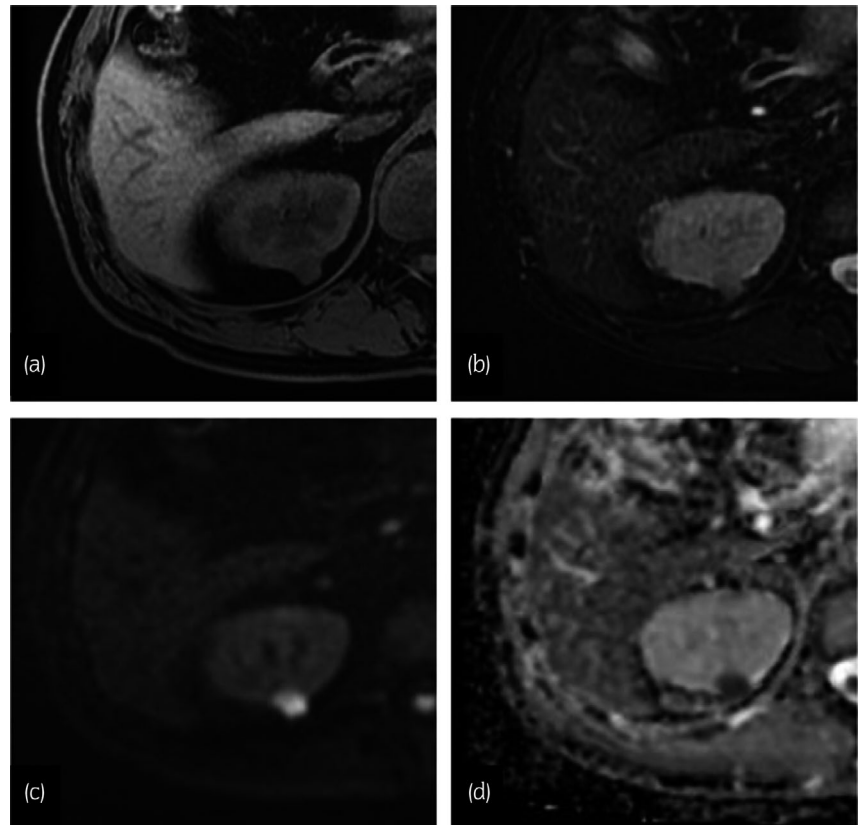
MRI images of the right kidney. (a) Fat-saturated T1-weighted imaging shows low signal intensity, (b) fat-saturated T2-weighted imaging shows slightly low signal intensity. (c) Diffusion-weighted imaging shows strong high intensity, and (d) apparent diffusion coefficient value is low.
